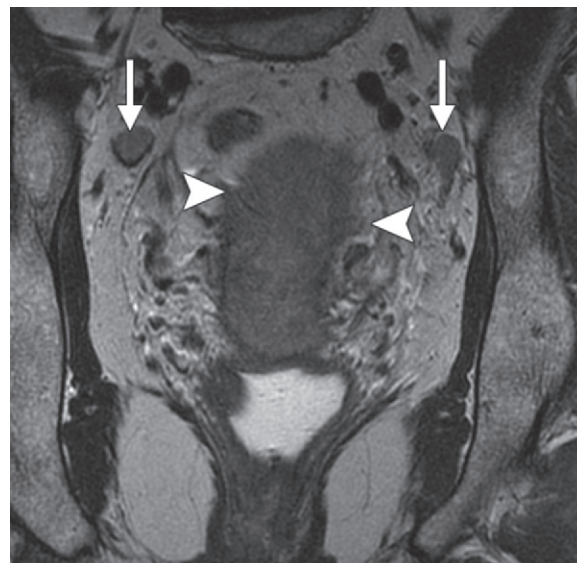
Metastatic lymphadenopathy. Coronal high-resolution T2-weighted FRFSE MR image shows a large cervical mass with bilateral parametrial extension (arrowheads) and bilateral external iliac lymphadenopathy (arrows). Lymph nodes have abnormal signal intensity, which matches that in the primary tumor. High-resolution MR imaging depicts abnormal alterations in nodal morphologic characteristics and signal intensity, even in normal-sized nodes, which increases its sensitivity for depicting disease.
